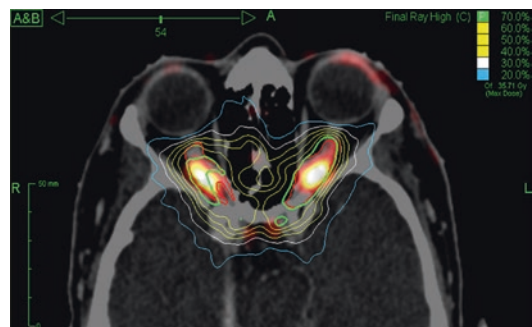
Treatment planning with PET/MRI to identify the full extent of the tumor, in particular bilateral optic nerve sheath meningiomas
